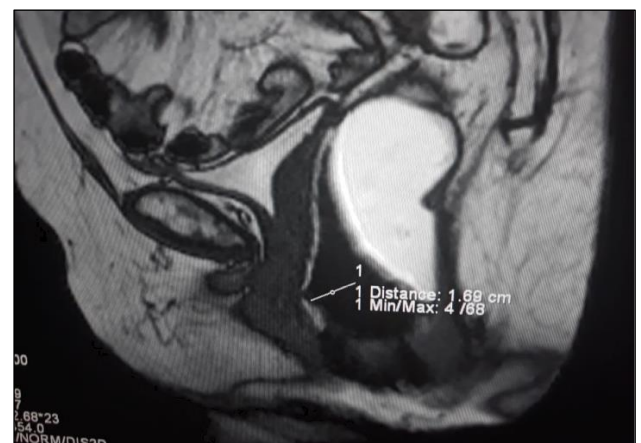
Sagittal MR image revealing evidence of anterior pouching of rectal wall above anal canal due to laxity of endopelvic fascia suggestive of anterior rectocele. Since outpouching measures less than 2 cms it is graded as small.
